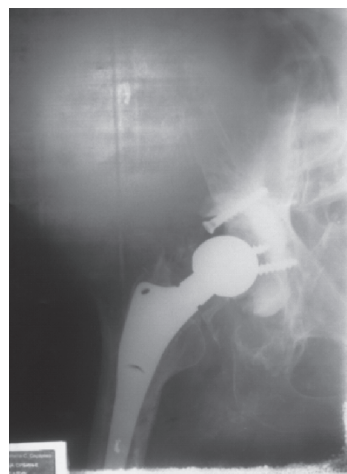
Postoperative radiography in the same patient
